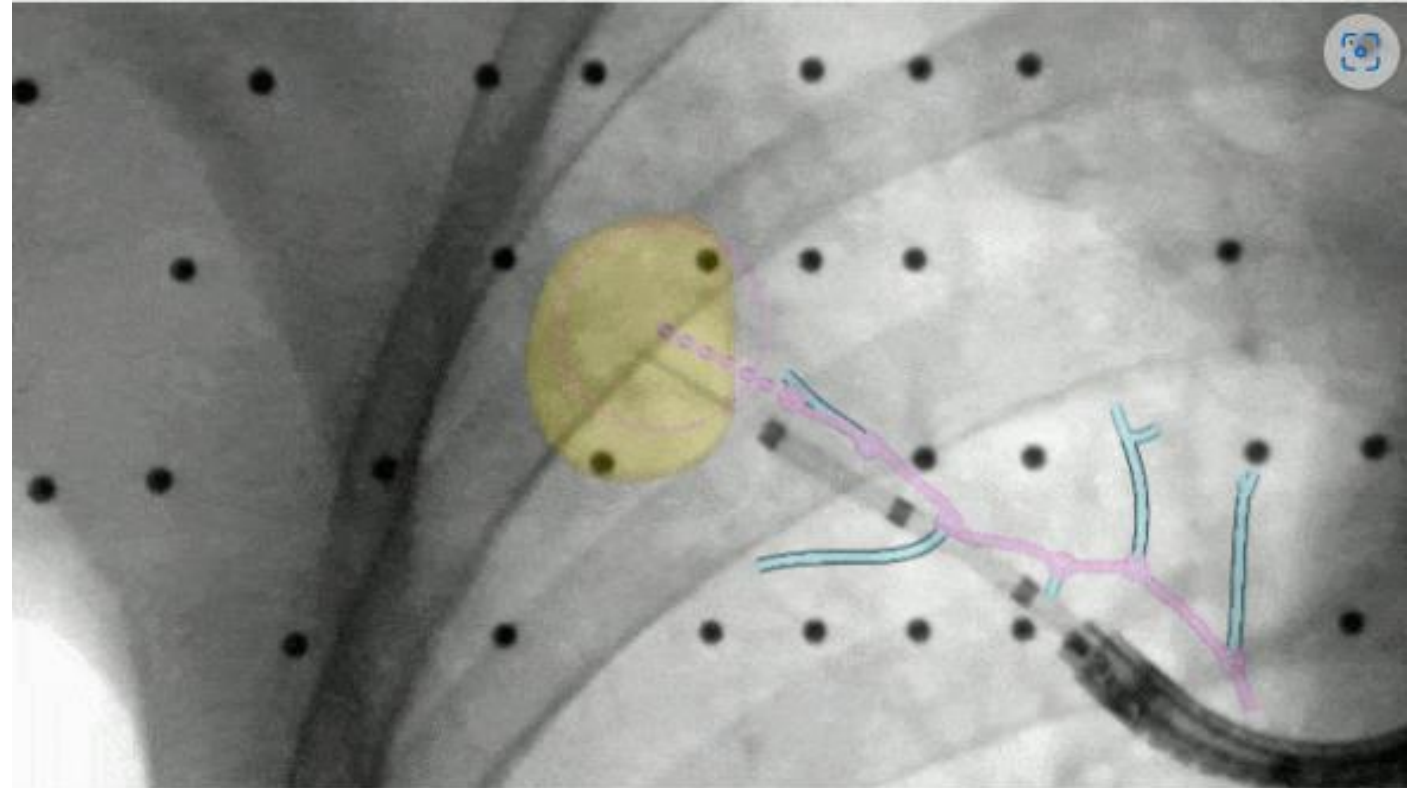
LungVision Platform. The platform integrates with available endobronchial modalities including bronchoscope, fluoroscope, and radial endobronchial ultrasound (REBUS) to present an augmented real-time pathway to a suspicious lung nodule. CT indicates computed tomography. *ut*
